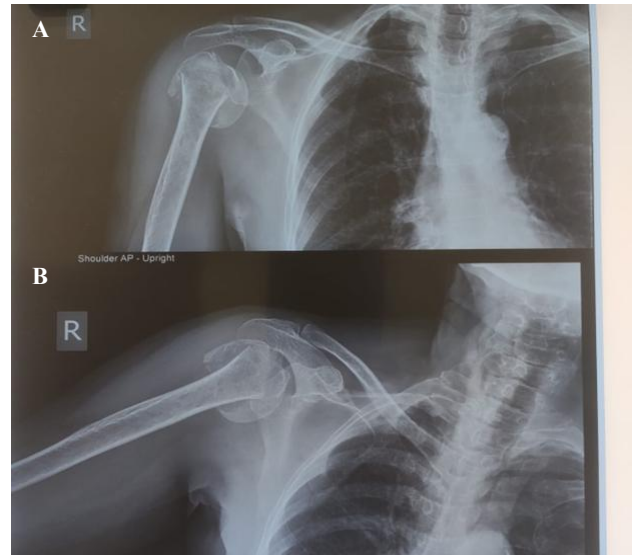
(A and B): Pre-operative radiograph.
